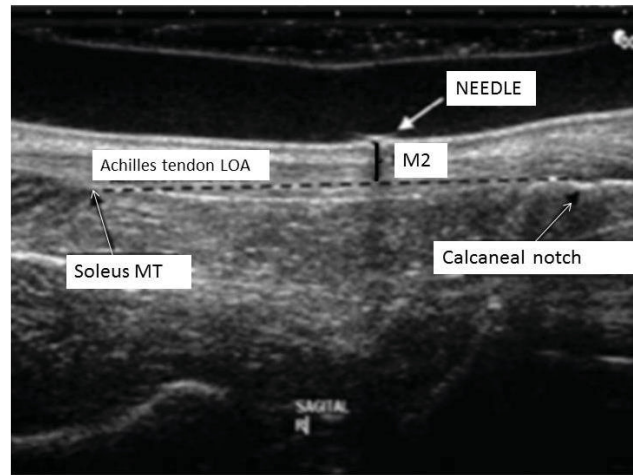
Ultrasound back view image used to determine the ankle joint moment arm.
